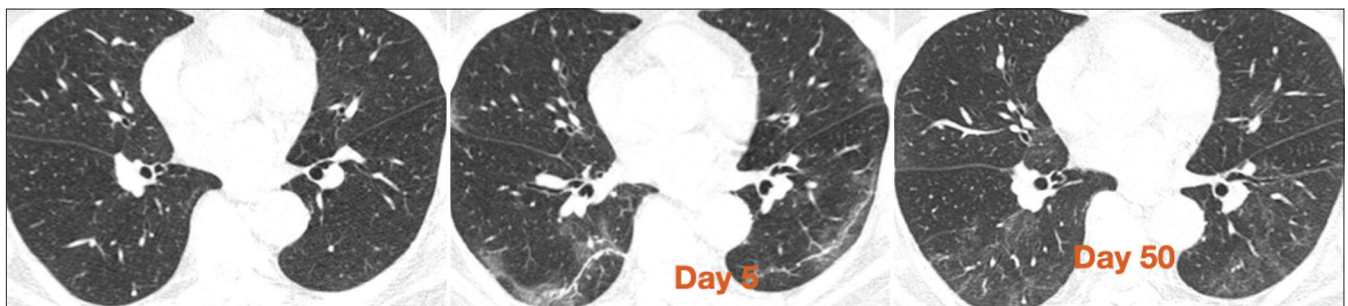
HRCT (A) COVID-19 pneumonia in resolving phase with subpleural curvilinear lines often termed fibrosis this on follow up scan shows total resolution
